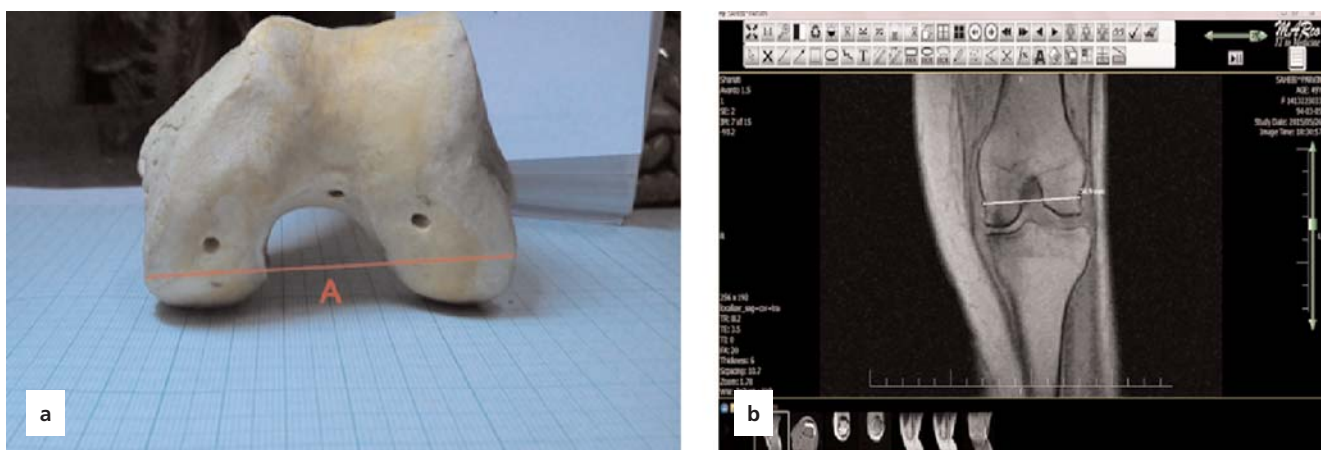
(a) Bicondylar line in distal femur and (b) intercondylar width on MRI image. [Color figure can be viewed in the online issue, which is available at www.anatomy.org.tr]
